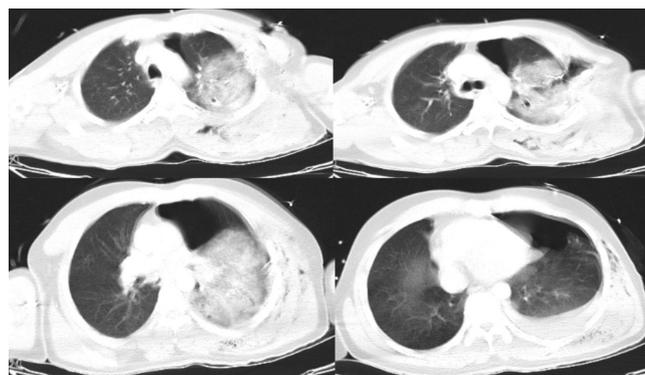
Thoracic computed tomography image obtained upon admission to the emergency department
